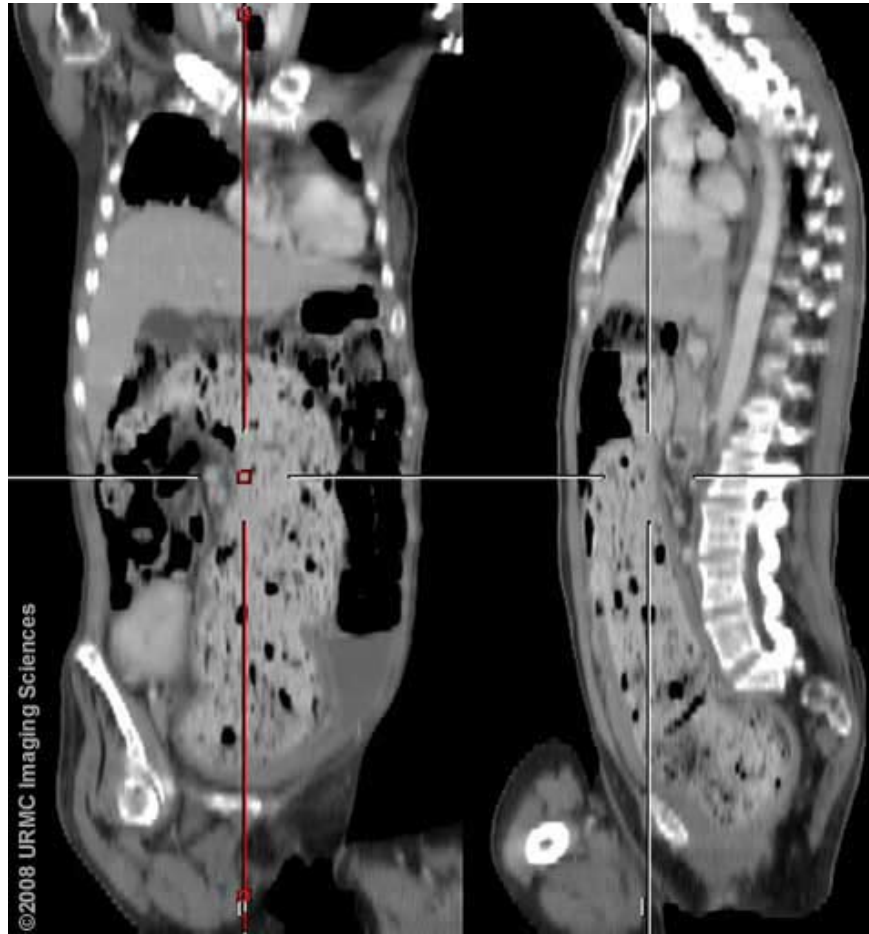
(Case 2): CT coronal and sagittal reformats show the fecal impaction to involve most of the sigmoid colon. Colonic wall thickening is evident.
